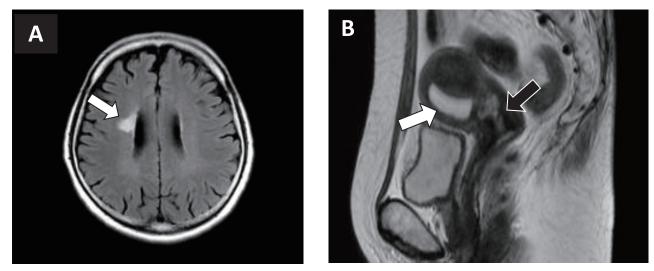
Brain and pelvic MRI.
